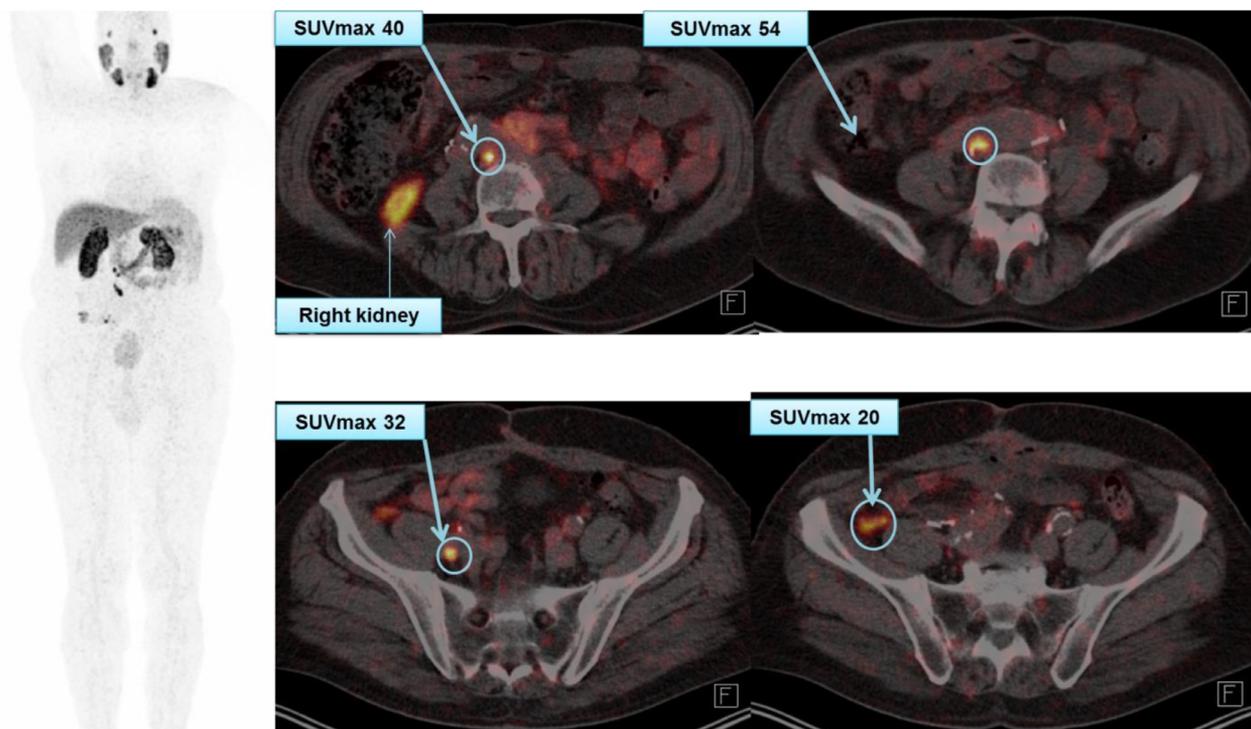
Cu-64 PSMA PET/CT in a patient restaged with progressive disease. Cu-64 PSMA PET/CT demonstrates multiple abdominopelvic lymph node metastases. MIP image and axial PET/CT fusion images were shown with arrows indicate positive findings with SUVmax of 54.
